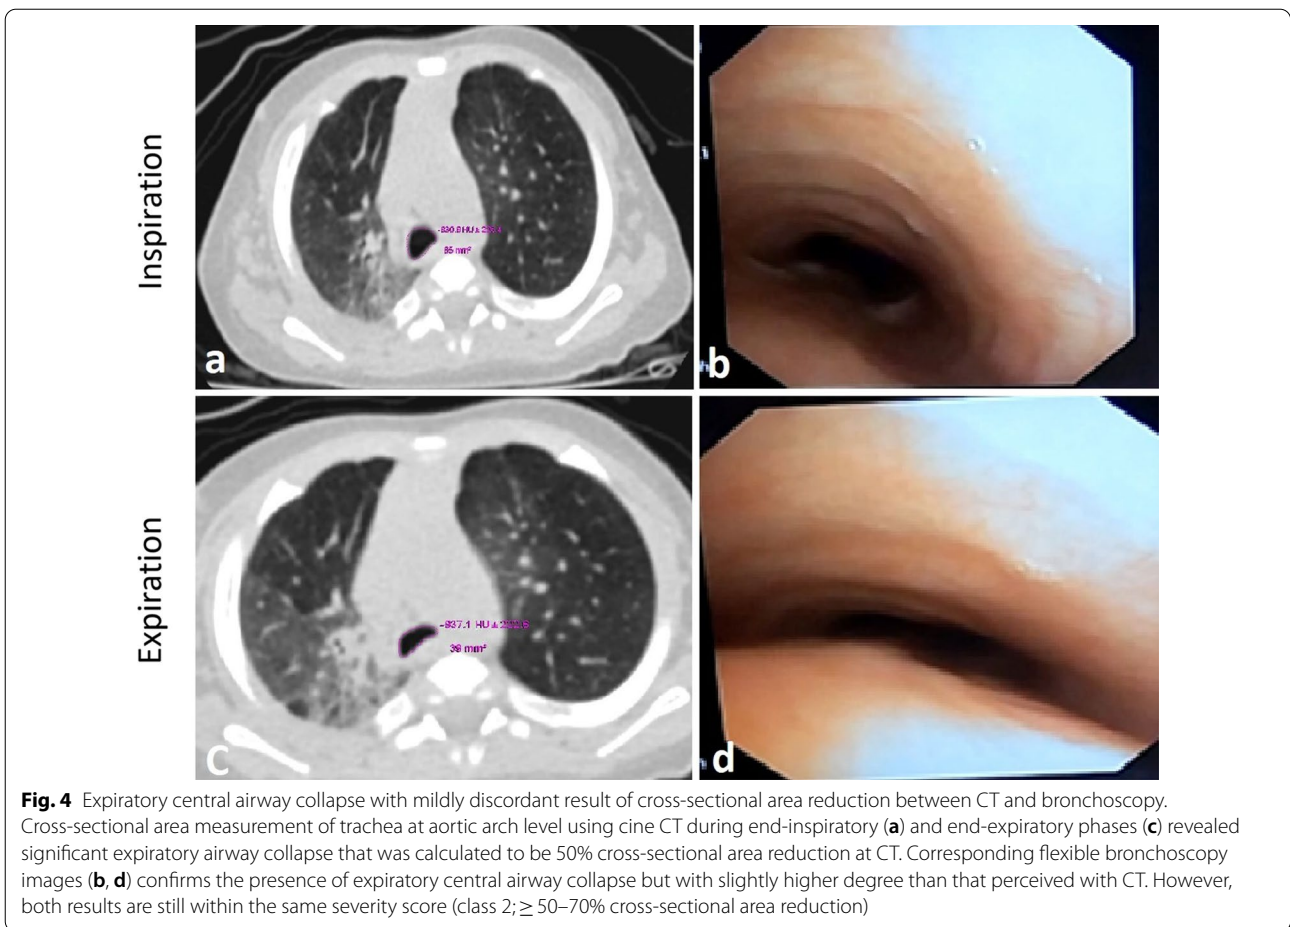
Expiratory central airway collapse with mildly discordant result of cross-sectional area reduction between CT and bronchoscopy. Cross-sectional area measurement of trachea at aortic arch level using cine CT during end-inspiratory (a) and end-expiratory phases (c) revealed significant expiratory airway collapse that was calculated to be 50% cross-sectional area reduction at CT. Corresponding flexible bronchoscopy images (b, d) confirms the presence of expiratory central airway collapse but with slightly higher degree than that perceived with CT. However, both results are still within the same severity score (class 2; ≥ 50 –70% cross-sectional area reduction)
